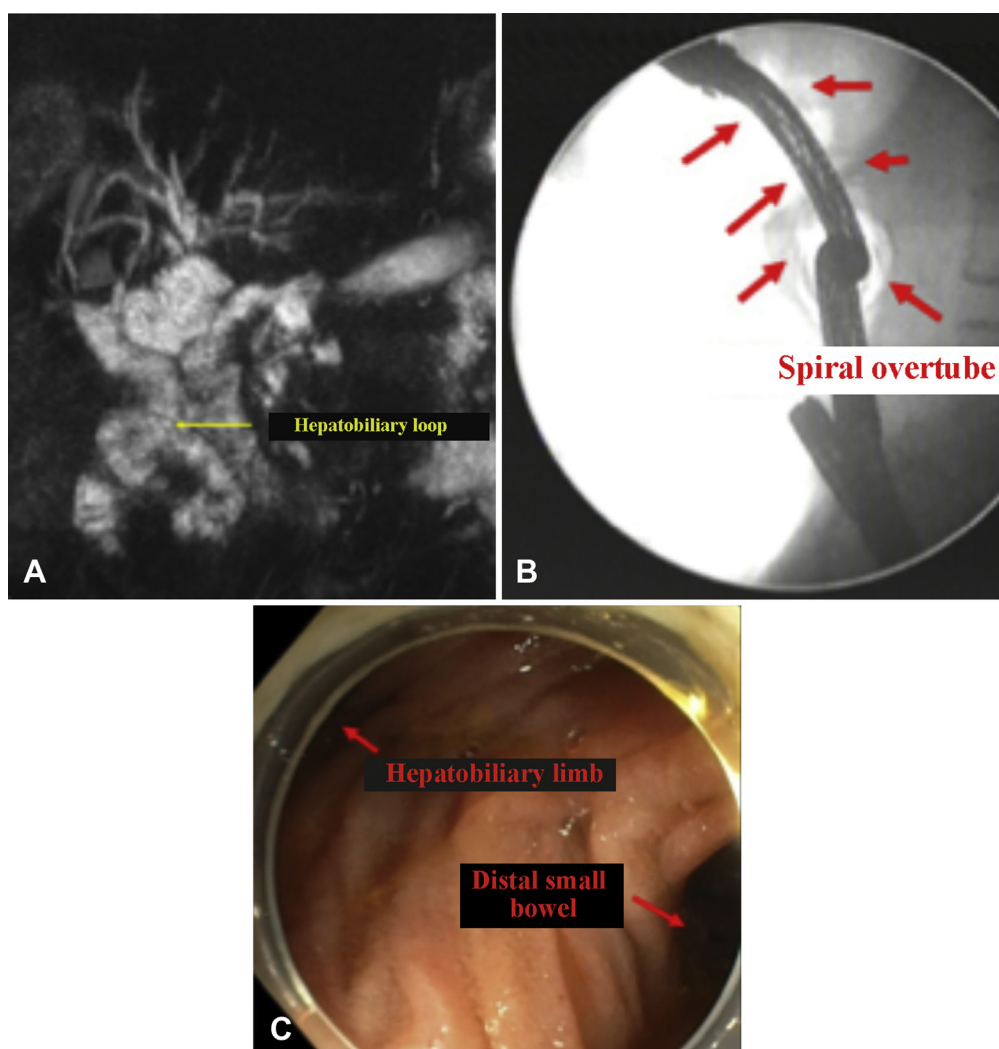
A, Magnetic resonance imaging. B, Fluoroscopy with spiral overtube (*red arrows*) and (C) endoscopic aspect of Roux-en-Y anastomosis with hepatobiliary limb (*red arrow*).
